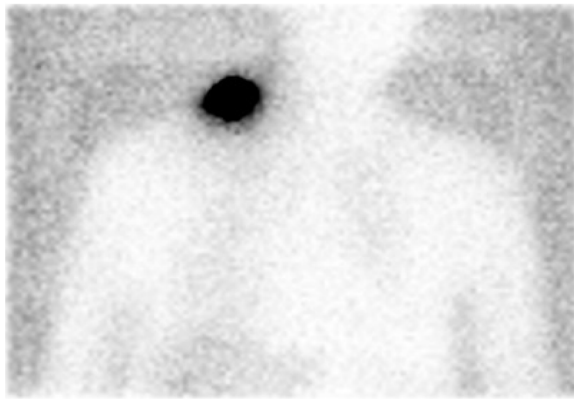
CT PET 1 hour post injection of Tc-99M: melanoma on right shoulder.
